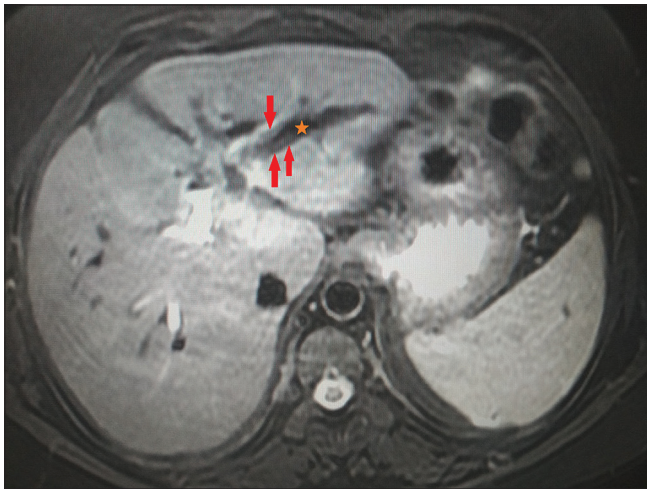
Axial T2-weighted image demonstrating central hypointensity involving left lobe of liver suggesting pneumobilia (star) with irregular wall thickening and ragged margins of the left hepatic duct (arrows). The findings were consistent with ascending cholangitis on MRI
